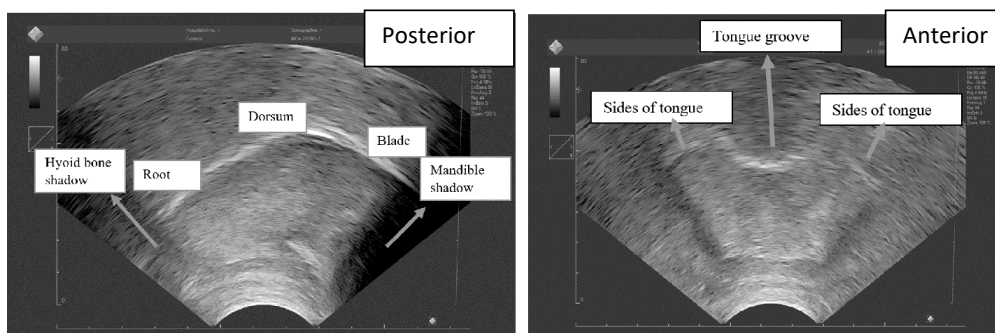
Ultrasound images of the tongue in sagittal (left) and coronal (right) planes.
